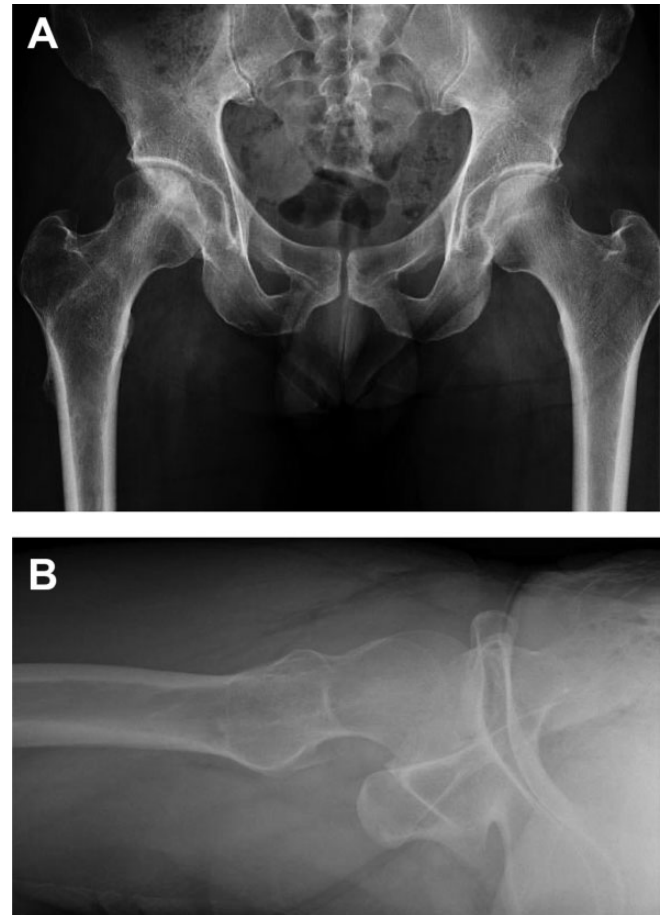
(A) Anteroposterior pelvic and (B) cross-table radiographs 28 months after surgery demonstrate remodeling of the cyst with preservation of the joint space.
